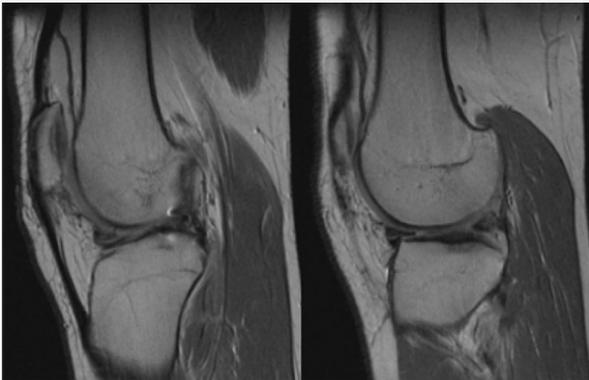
Sagittal images of MRI enhanced in DP sequence that show alterations of the signal in the transplanted meniscus: a horizontal hyper-signal is observed at the level of the meniscal body and another diffuse hypersignal at the level of the posterior horn, common and normal findings in a meniscus transplanted that should not be confused with pathological findings.
